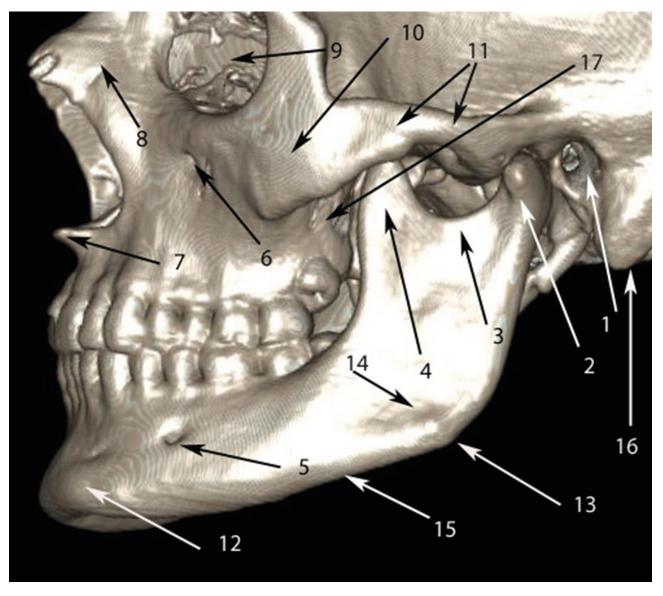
Facial bones on the 3D scan (lateral view) of multislice computed tomography. *Numbers* with *arrows* denote the following anatomical structures: 1 – external auditory meatus; 2 – processus condylaris; 3 – incisura mandibulae; 4 – processus coronoideus; 5 – mental foramen; 6 – infraorbital foramen; 7 – anterior nasal spine; 8 – nasal bone; 9 – orbit; 10 – *zygomatic bone;* 11 – *zygomatic arch* (formed by the temporal process of the *zygomatic bone and the zygomatic process of the temporal bone);* 12 – mental spine; 13 – angle of mandible; 14 – masseteric tuberosity; 15 – left mandibular body; 16 – mastoid process; 17 – maxillary tuberosity.
